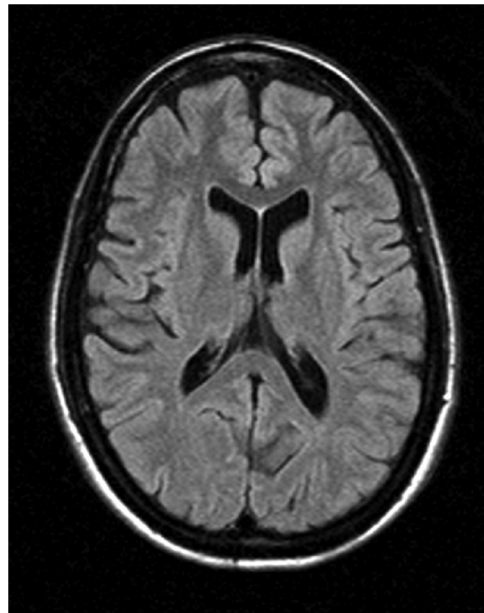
Brain MRI scan.
